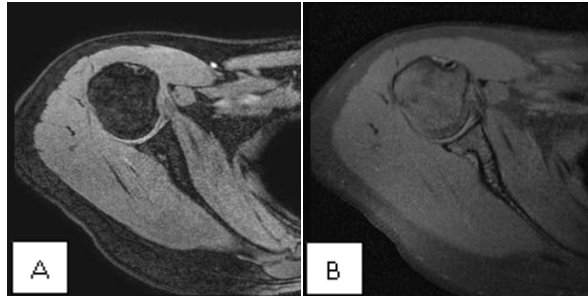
MRI Shoulder Joints on 2 Different Sequences, (a) Axial T1 FFE (b) Axial T1 SPIR.
